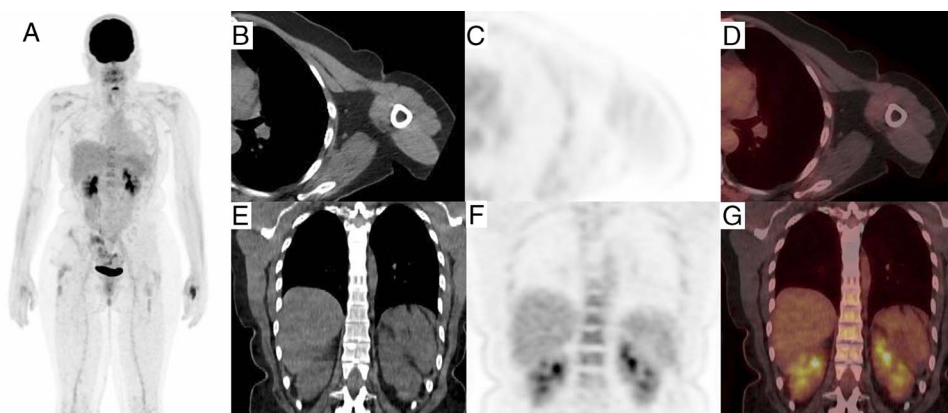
A follow-up ^{18}F -FDG PET/CT was performed 3 months later: MIP (A), axial CT, ^{18}F -FDG PET, and fused ^{18}F -FDG PET/CT of the left hemithorax and upper arm (B–D), and coronal CT, ^{18}F -FDG PET, and fused ^{18}F -FDG PET/CT of the chest and abdomen (E–G); the small volume avid left axillary nodes, left deltoid uptake, and diffuse splenic and marrow uptake have resolved, consistent with the working diagnosis of SIRS related to COVID-19 vaccination. Although not a common response to vaccination, given the world wide mass immunization programs and the potential of recurrent seasonal boosters, SIRS may be observed with increasing frequency on ^{18}F -FDG PET/CT. In conjunction with the appropriate clinical history and laboratory findings, the diagnosis of SIRS should be considered if FDG uptake is demonstrated in the superficial aspect of the deltoid muscle, ipsilateral axillary nodes, and diffusely within the spleen and bone marrow.
